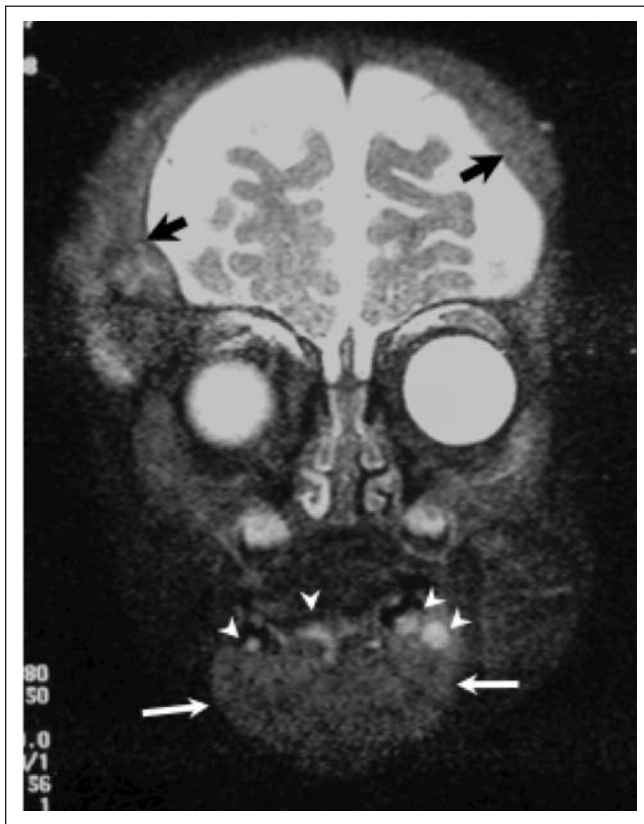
Coronal T2-weighted MR images show (a) A soft tissue mass replacing mandibular corpus (white arrows) with invasion of tooth roots (arrowheads).
